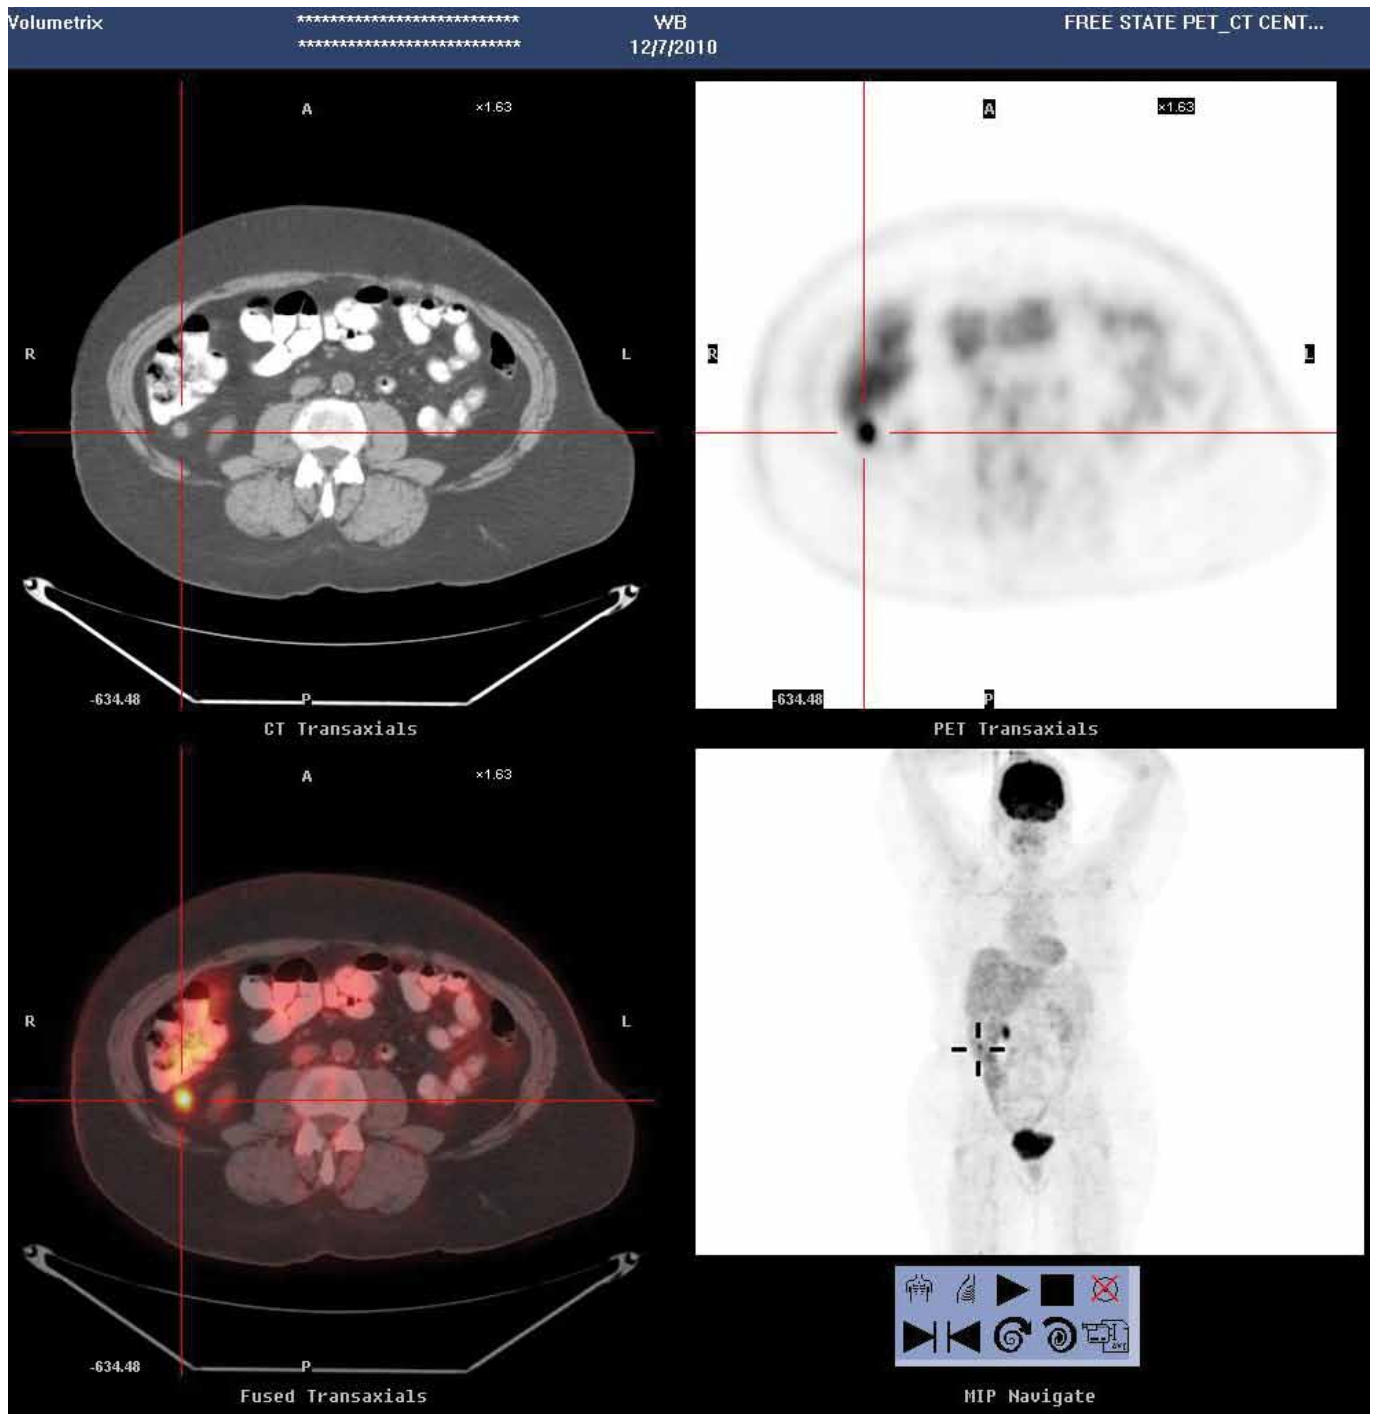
Transaxial CT, PET and fusion images with the FDG-avid nodule in the tip of the appendix.
